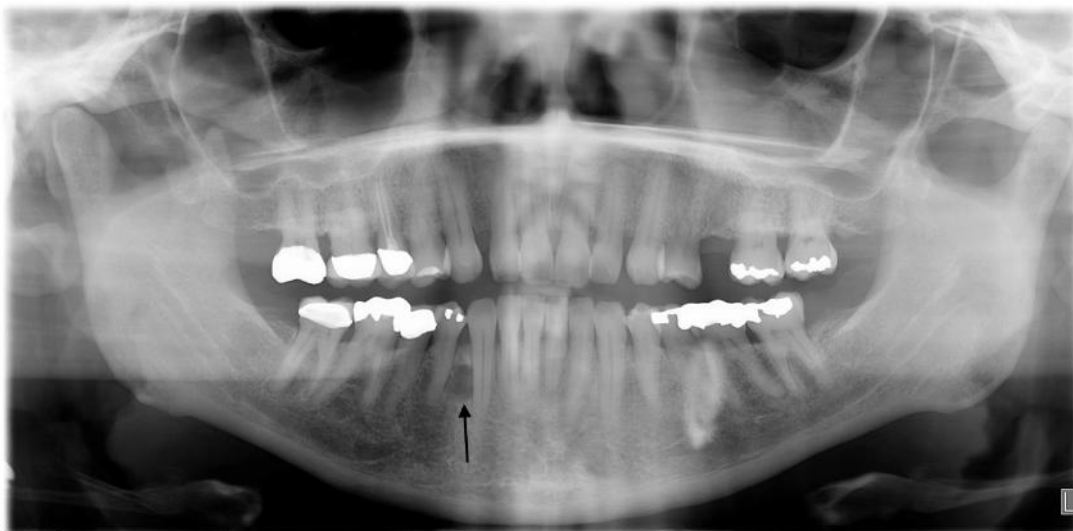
Orthopantomograph showing a well-circumscribed radiolucent area between #27-28 (arrow).
